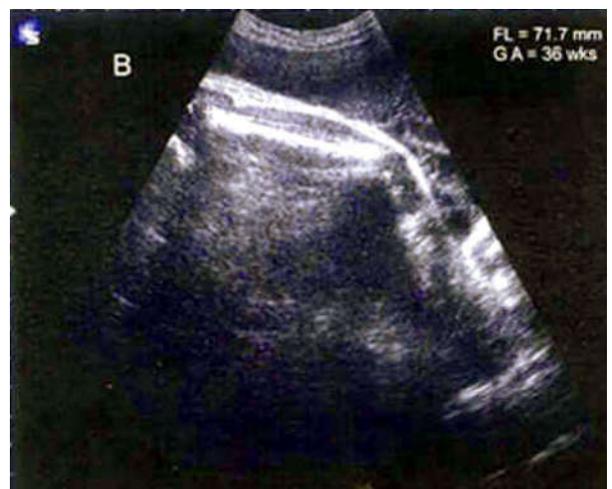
B: Transabdominal sonographic view of femur length in a 36 weeks fetus (real time scan)
